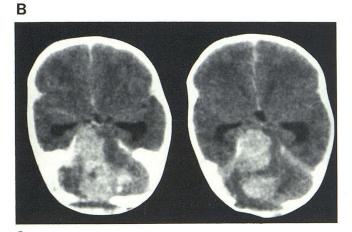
Case 1. A, Noncontrast CT at birth shows increased density in right cerebellopontine angle with little mass effect and hydrocephalus. Noncontrast (B) and contrast (C) scans 1 month later. Further enlargement of high-density right cerebellar mass now involving midline structures and left cerebellum. Lesion enhances after contrast administration. Fourth ventricle is obliterated and hydrocephalus is present. There was "hematoma" evacuation 3 weeks earlier.
